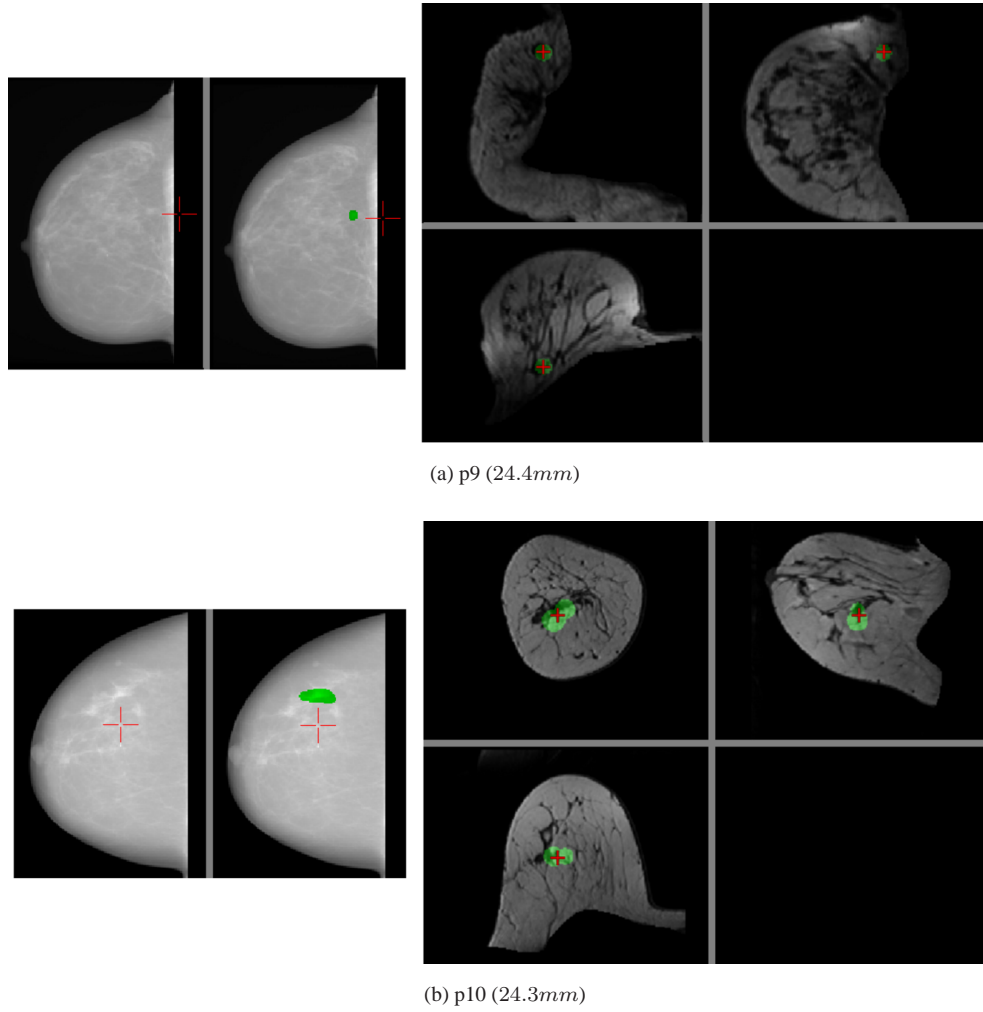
Cases for which the registration error was high. On the left are shown the X-ray mammograms and on the right the MRIs of (a) p9 and (b) p10.
